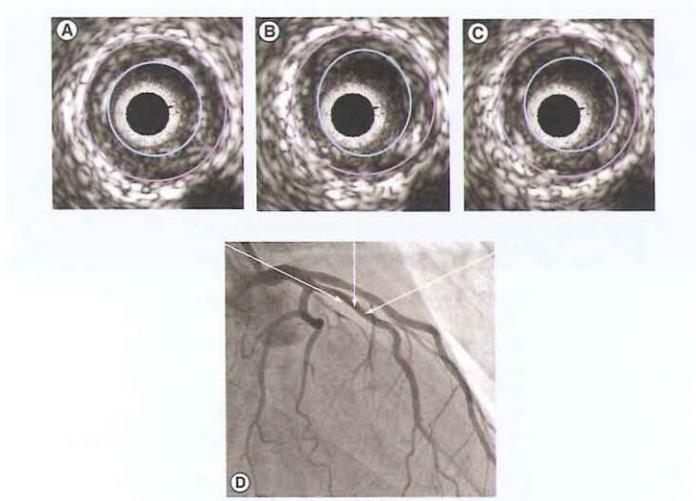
(A, B & C) show three consecutive intravascular ultrasound images of the proximal left anterior descending (D), which is disease-free angiographically. Note that the intravascular ultrasound images show a plaque burden of 50%.
